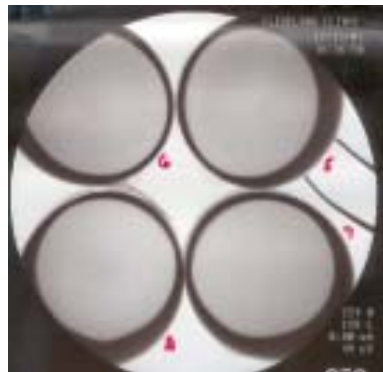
Top View: MEMS chips in a saline bath did not demonstrate visibility radiographically.
